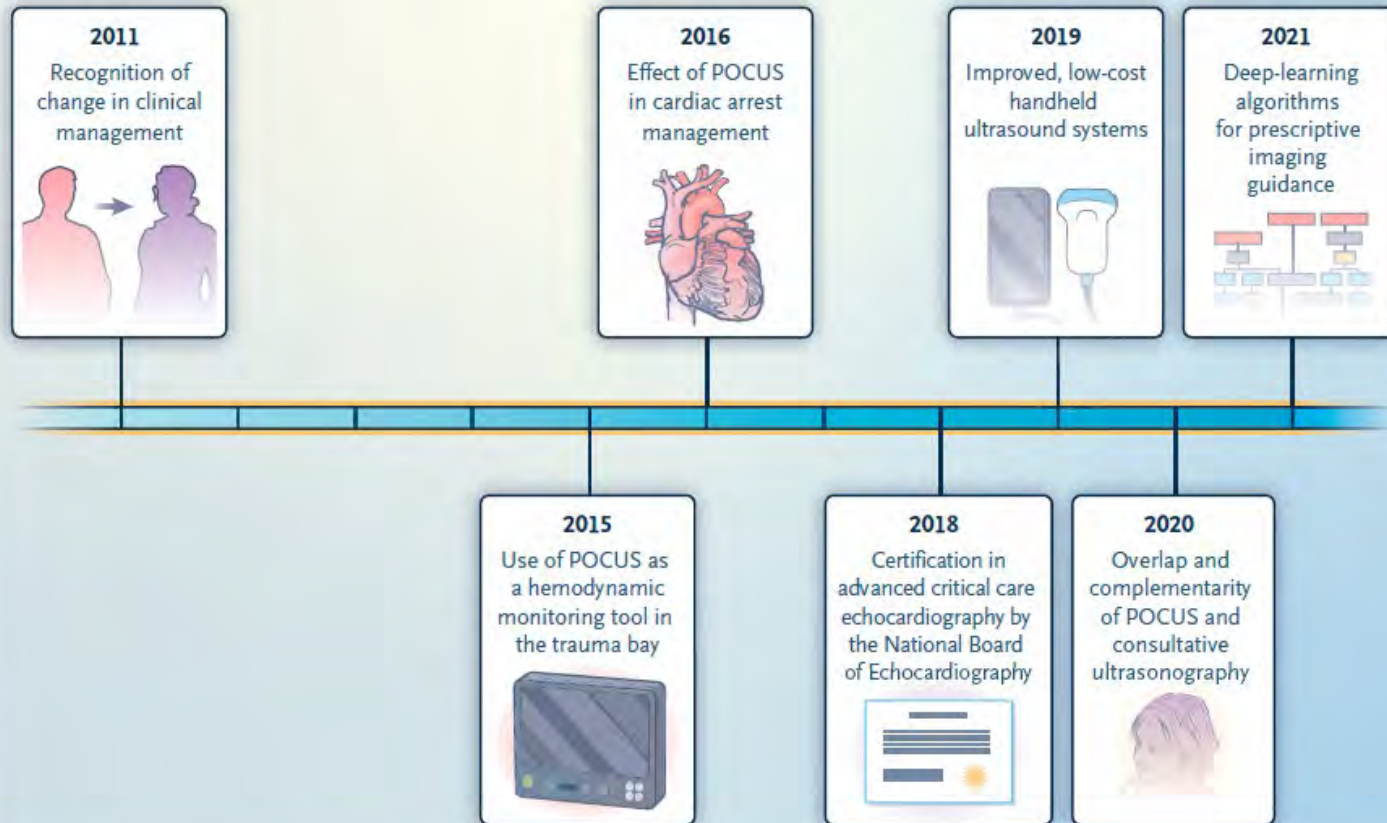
Evolution of Point-of-Care Ultrasonography (POCUS) during the Past Decade.
